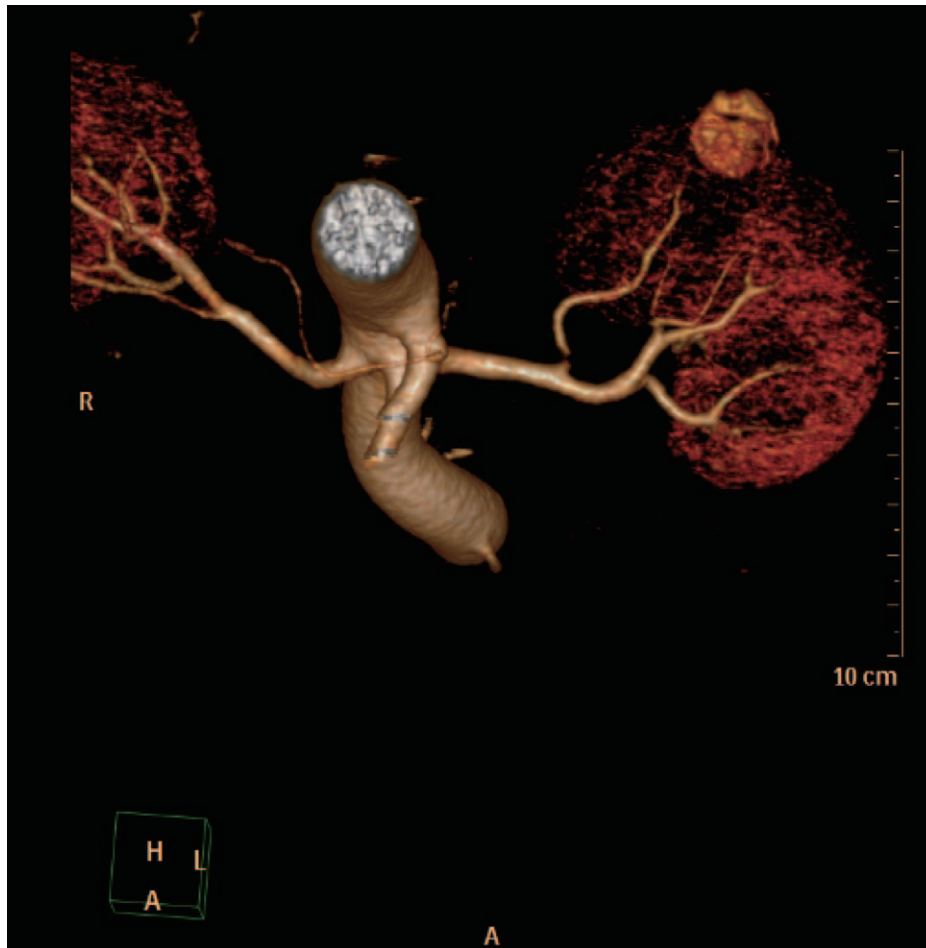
Renal artery CTA 3D reconstruction. CTA=computer tomography angiography.
